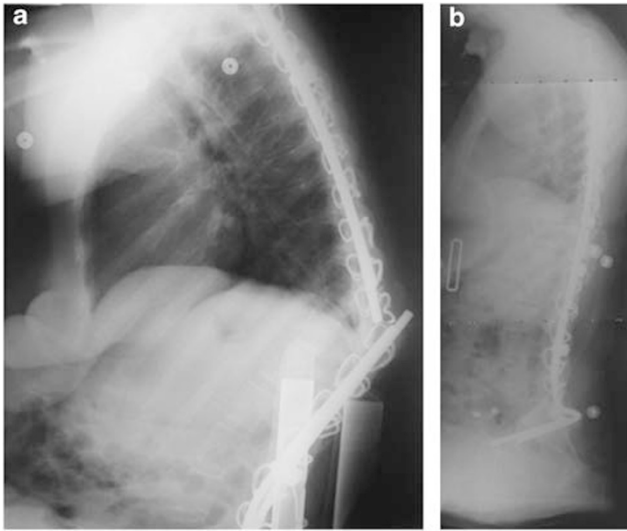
Radiographs of case 1 before (a) and after (b) surgical repair.
